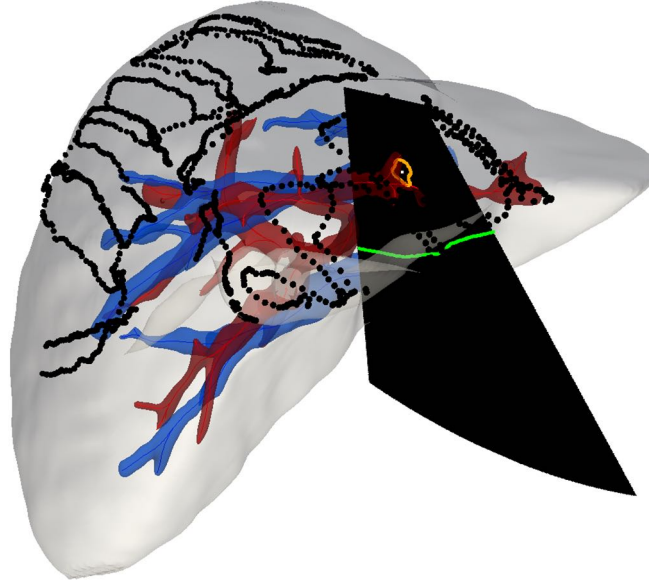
Intraoperative ultrasound features. Preoperative liver model (gray), portal vein (red) and hepatic vein (blue) with rigidly registered data consisting of sparse anterior surface points (black) and iUS features including the posterior surface (green), vessel contour (orange), and vessel centerline point (white).
